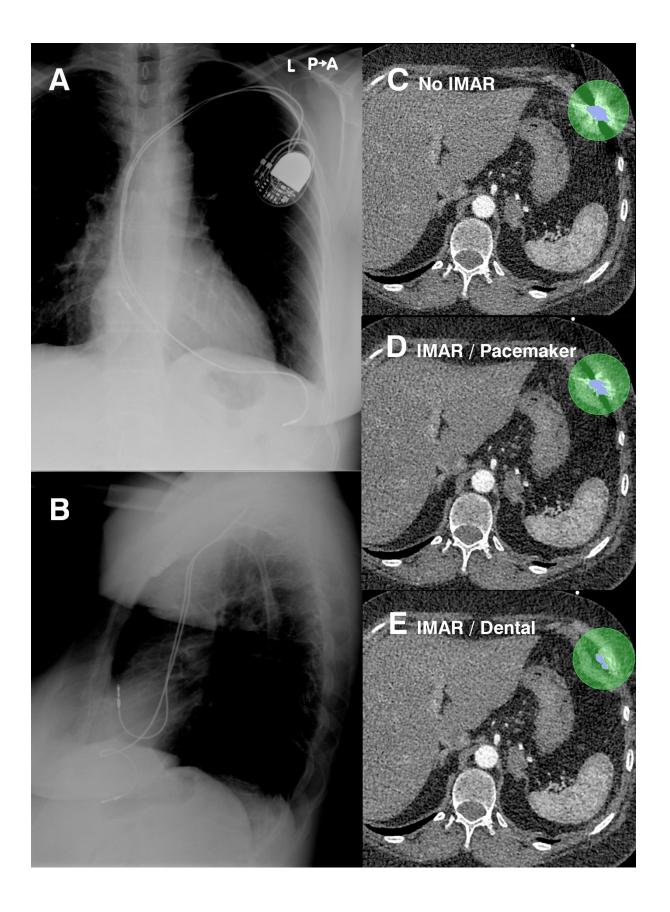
Posteroanterior (A) and lateral (B) chest X-ray shows right ventricular lead projected under the left diaphragm. Native (C) and IMAR-filtered (D, E) computed tomography images showing reduction of the area of metallic artifacts around the lead tip, with best results on dental preset (E)
